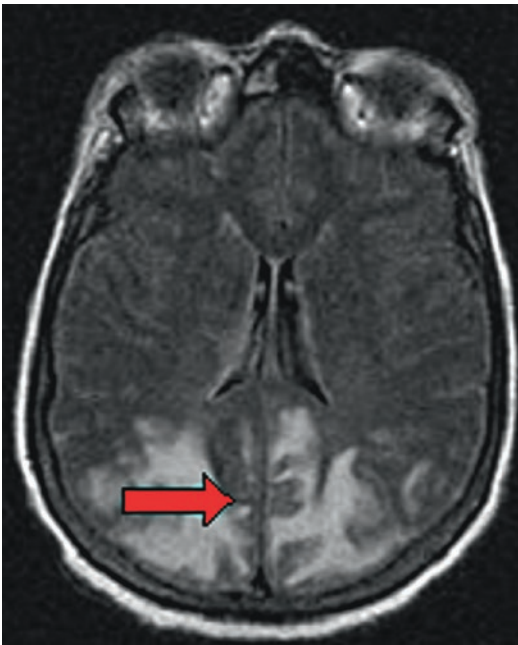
Axial flair image of MRI of patient with PRES, demonstrating high signal activity (*arrow*) confined to the white matter in a posterior distribution (Image courtesy of Barton F Branstetter IV, MD)
